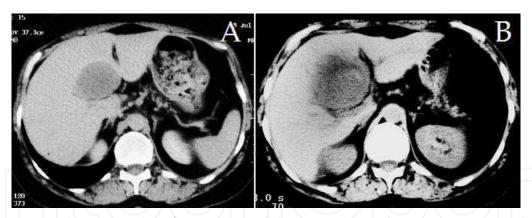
Computed tomography of a patient with liver metastasis from gastrointestinal stromal tumor (A). RFA with cooling of bile ducts was performed (B).
